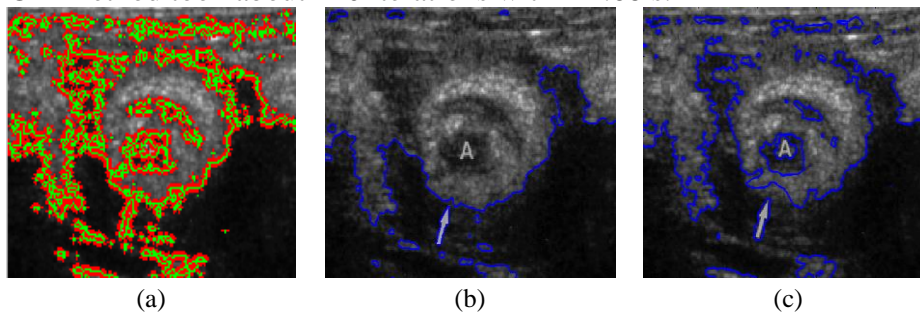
Experiments on ultrasound image of appendix. The final results using the C–V, SGLACM, and proposed methods are shown in the first, second, and third columns, respectively. The parameter of $\alpha=0.1$ and $\sigma = 5$.
